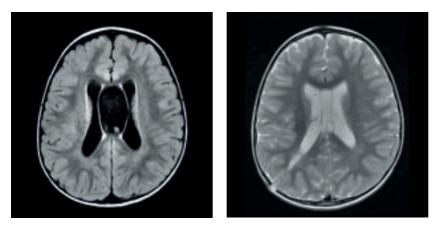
These MR images are obtained from a patient with a symptomatic cyst of the septum prior (left) and after (right) a right parietal endoscopic fenestration. The dual sites of fenestration on either septal leaflet are apparent. The postoperative image also demonstrates the return of the septal leaflets to a parallel orientation confirming decompression.
